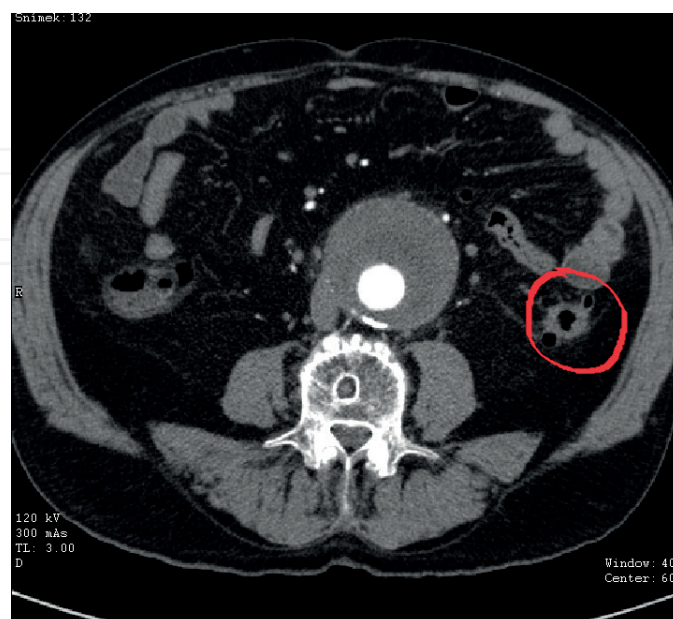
AAA and stenotic colon cancer (CTA).
